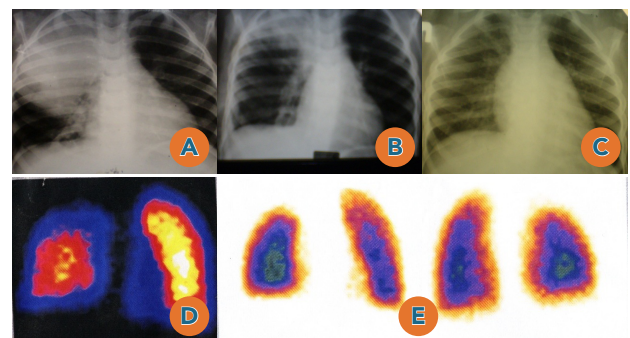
Patient C. 3 years. A - Preoperative X-ray: Major hydatid cyst in the upper lobe of the right lung. B - postoperative X-ray at discharge (12th day). C - chest X-ray 1 year after surgery. D - pulmonary scintigraphy (perfusion) performed 1 year after surgery. E - postoperative pulmonary scintigraphy of patient C. performed 2 years after surgery
